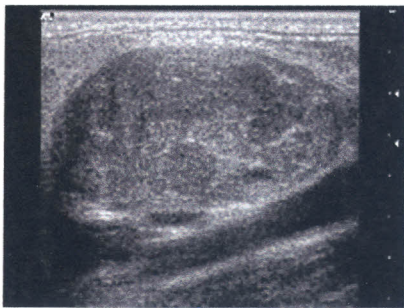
Grey scale ultrasonography scans of lymph nodes
